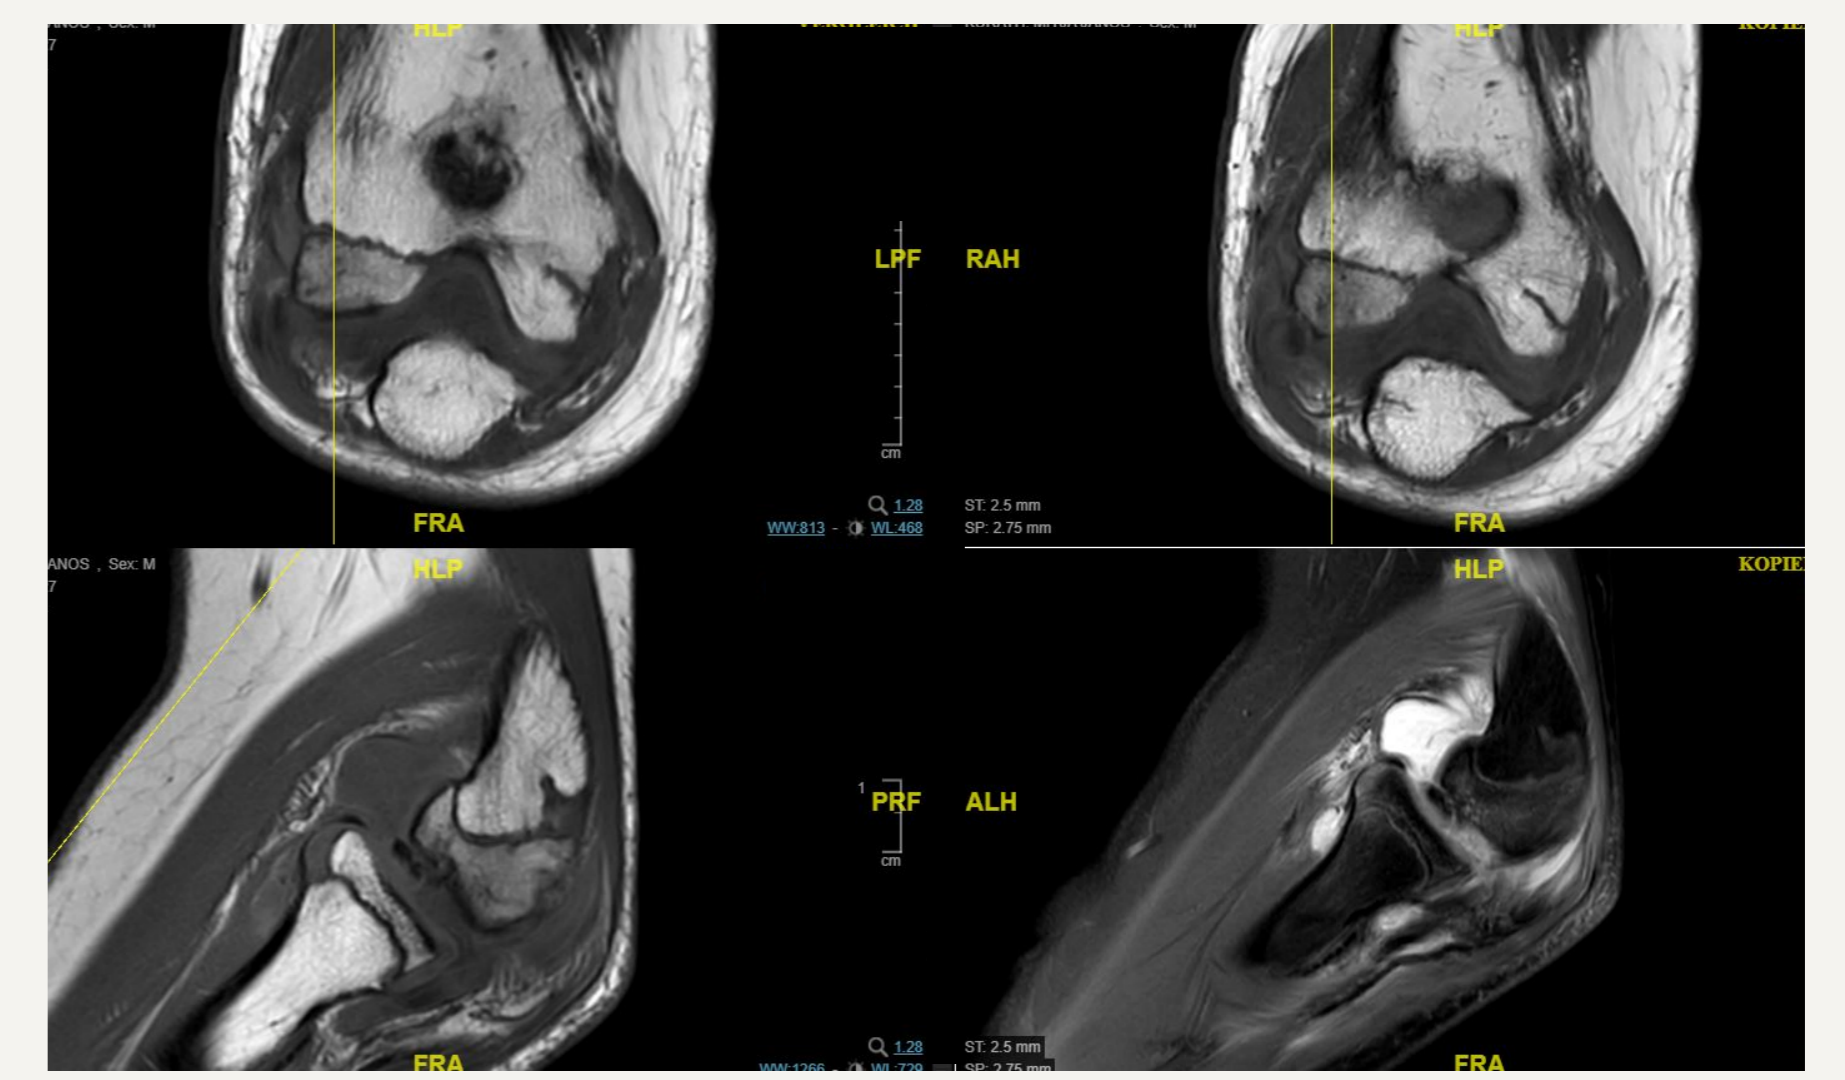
MRI, deformity of the humeral capitulum with a loose fragment, concomitant synovitis and joint effusion, suspicious for a chronic osteochondral lesion and fishtail deformity of the distal humerus
